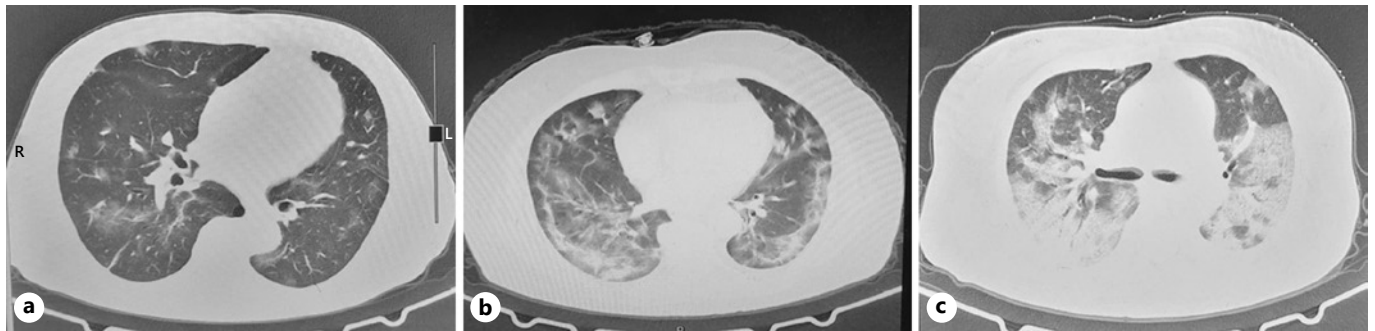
Representative chest CT images at auscultation. Multiple ground-glass opacities (a); patchy ground glass and fibrous stripes (b); patchy ground glass opacities and consolidation (c).
